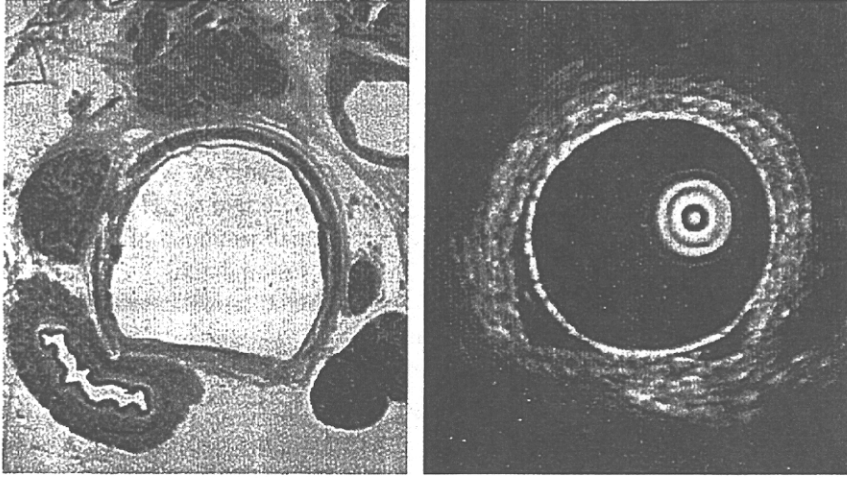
Endobronchial ultrasonographic (EBUS) image of normal trachea.
